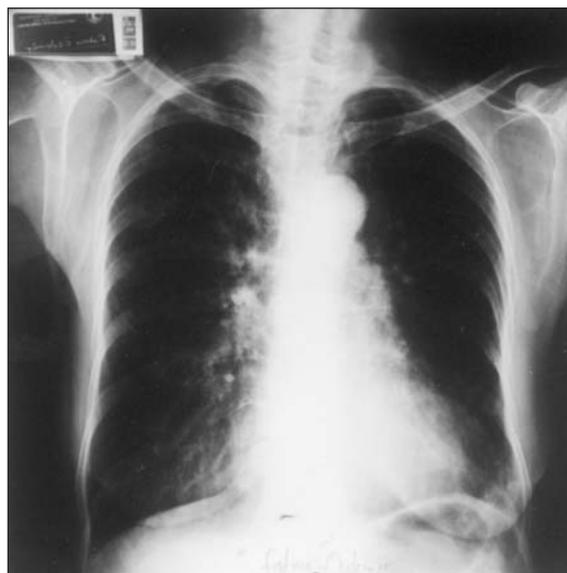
Postero-anterior chest x-ray showed hyperinflation and bilateral basilar reticulonodular opacities.
